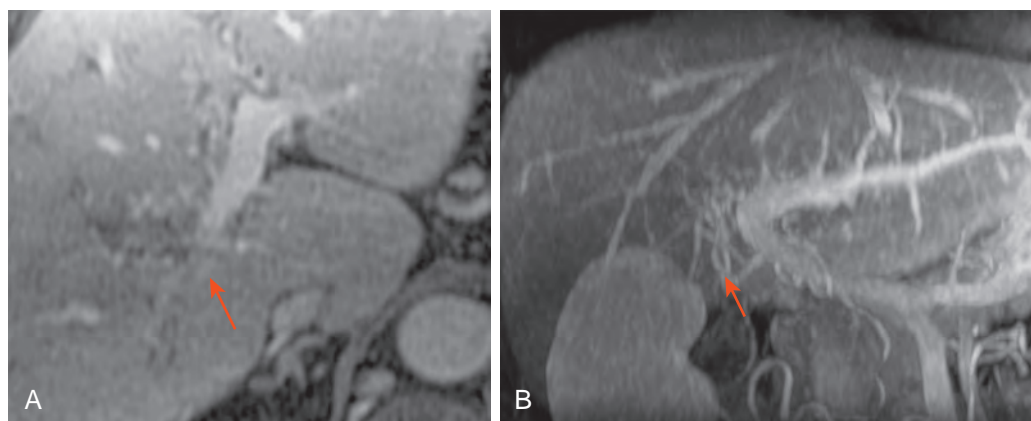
Intrahepatic portal vein thrombosis: MRI findings. A. Contrast-enhanced multiplanar reconstruction of SD-LAVA sequence shows thrombosis of the intrahepatic portion of the right hepatic vein (arrow). B. Thin-slab maximum intensity projection three-dimensional gradient-echo image shows the portal vein thrombus and early venous recanalization (arrow). (Case courtesy Roberto Schuman, MD.)
